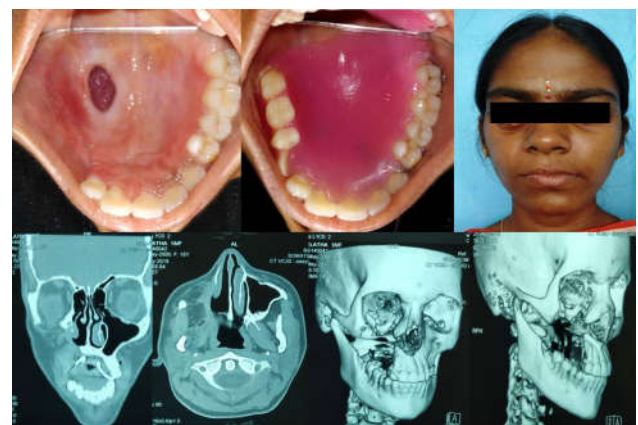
two years post-operative follow up, clinical and computed tomography of facial bones photographs
